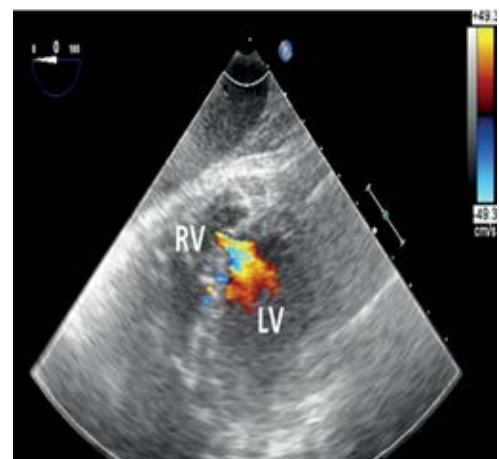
Trans thoracic echocardiography shows shunt flow from the left ventricle to the right ventricle.
